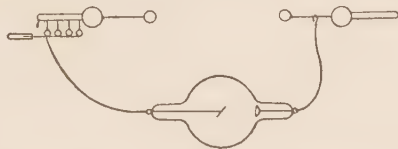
Shows an X-ray tube connected in series with a multiple spark gap, attached to a Static Machine.
